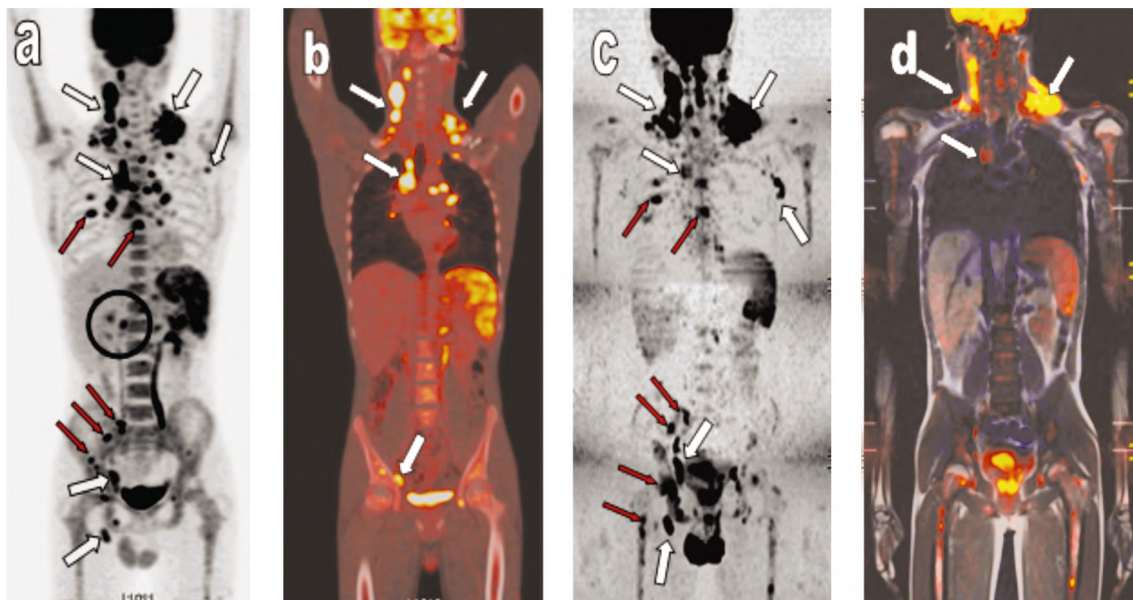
PET-CT versus WB-DWIBS in 14 years old boy. (A) MIP - PET figure. (B): Fused coronal PET-CT (bone window) figure. (C): Inverted grey scale MIP WB-DWIBS image. (D): Color coded fused coronal WB-T1 and WB-DWIBS images. Both PET-CT and DWIBS demonstrated nodal involvement at cervical, left axillary mediastinal, pelvic and inguinal regions (white arrows). PET-CT demonstrated diffuse and focal splenic involvement. Splenomegaly was seen on DWIBS images, thus considered positive. Multifocal osseous (vertebral, ribs, pelvic bones, proximal femoral and proximal humeri) lesions were also demonstrated by both PET-CT and DWIBS images (red arrows). Abdominal nodal involvement was clearly seen only by PET-CT. (circle).
